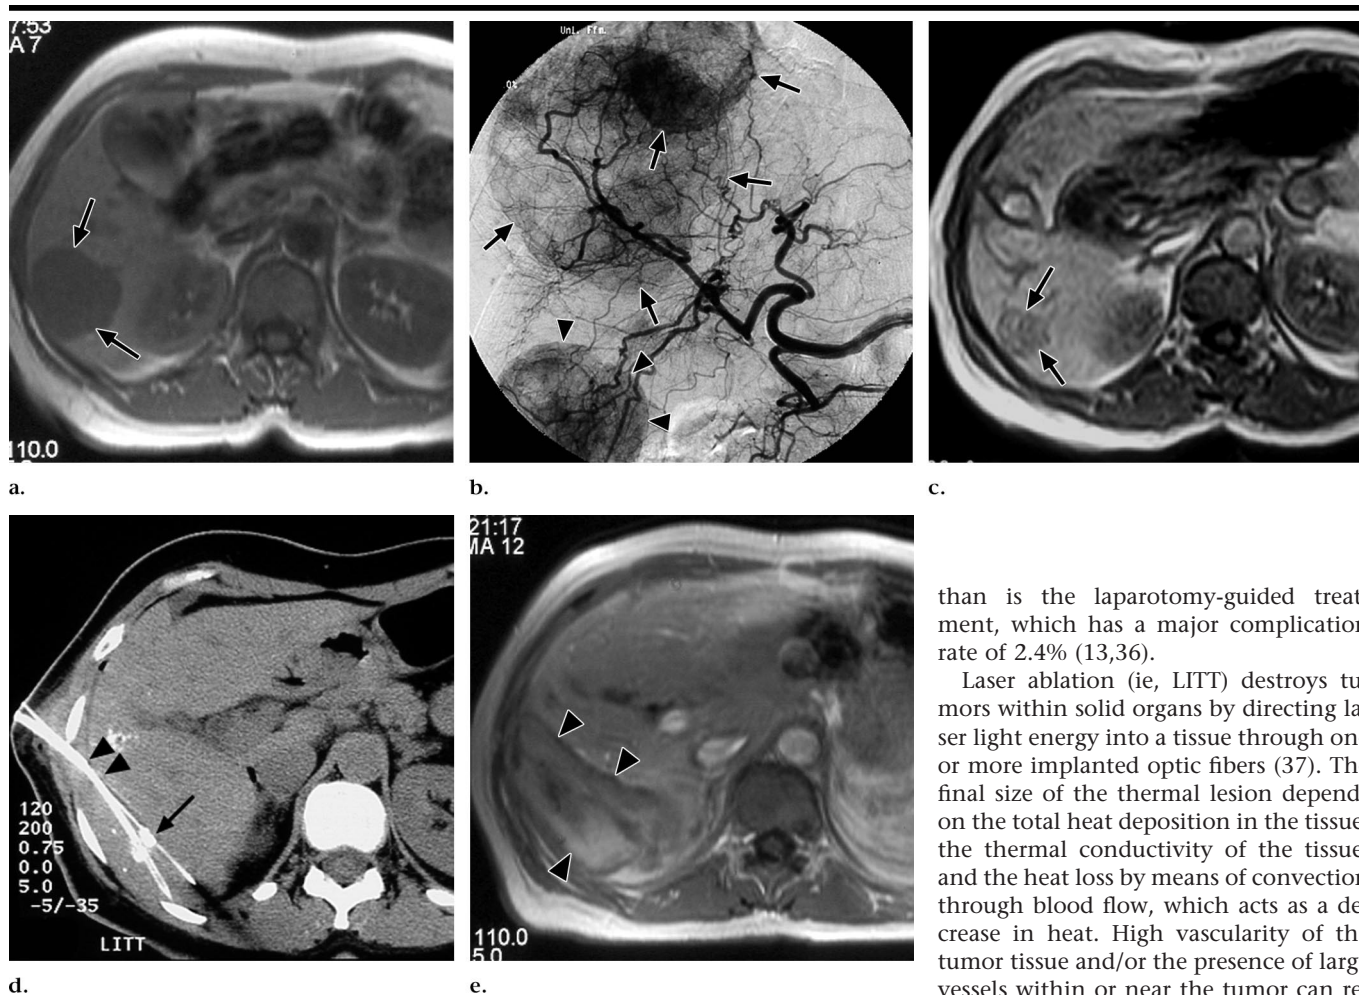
Images obtained in a 62-year-old woman with newly developed liver metastases of colorectal carcinoma. (a) Transverse gradient-echo T1-weighted MR image (135/6; flip angle, 80°) shows a large liver metastasis (arrows) in segment VI. In the coronal orientation, the lesion was 55 mm in diameter. (b) Frontal angiogram obtained during the first course of TACE reveals the hypervascularity of the target metastasis (arrowheads) and the additional target lesions (arrows) that were not shown in a. (c) Unenhanced transverse gradient-echo MR image (140/12; flip angle, 80°) obtained after the third course of TACE shows a 50% decrease in tumor volume (arrows). (d) Unenhanced transverse CT scan obtained after the third course of TACE during the application of the laser catheters (arrowheads) shows residual tumor lesions with attenuating area (arrow) caused by retention of iodized oil. (e) Contrast-enhanced transverse MR image (135/6; flip angle, 80°) obtained 24 hours after LITT demonstrates ablated volume (arrowheads), characterized by a low signal intensity area surrounded by a hyperintense rim. Area of necrosis is larger than original lesions.
